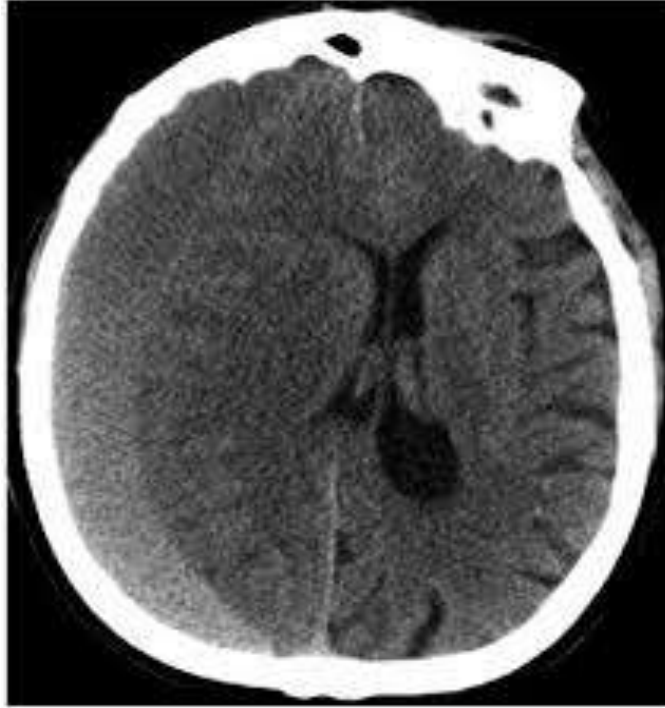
CT Brain Chronic Subdural hematoma, (Robbins, 1987).
